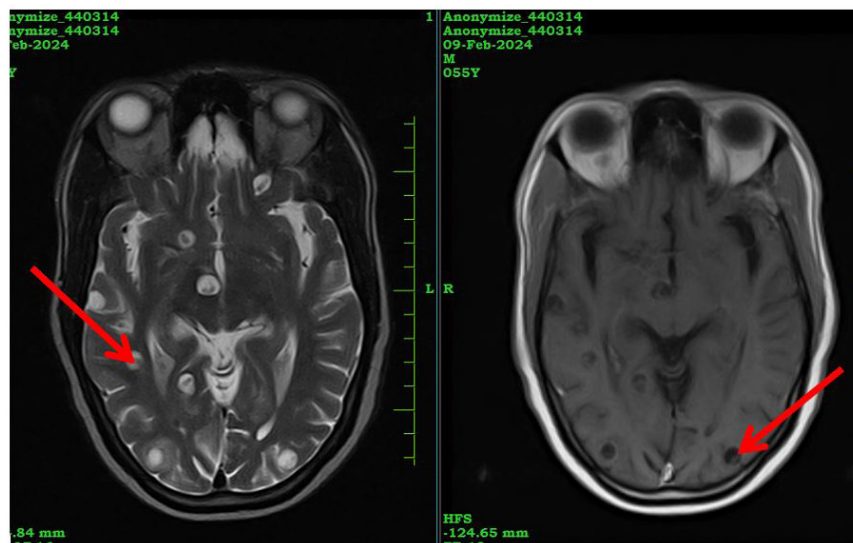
Brain MRI scans: Red arrows show cysticerci bright on T2 image (left) and dark on T1 image(right)
